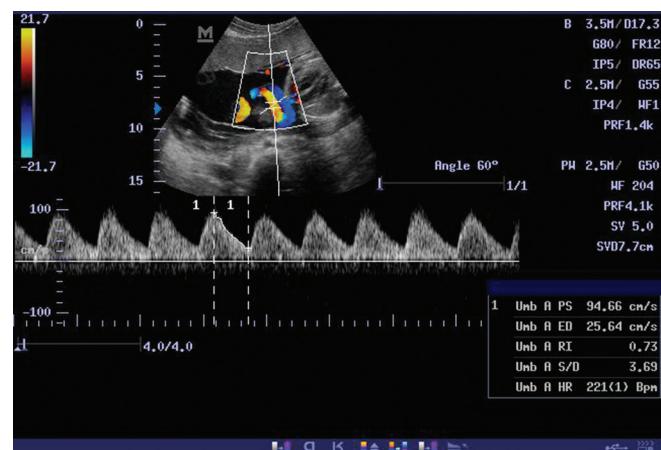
Duplex Doppler sonogram of the umbilical artery in one of the hypertensive patient at an angle of 60°, showing uniform uni-directional blood flow and peak systolic velocity of 94.66 cm/s and resistance index of 0.73
